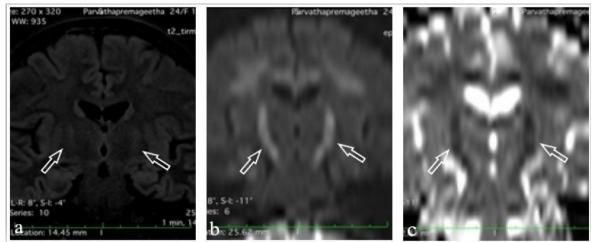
MRI coronal image of FLAIR (a), coronal reformatted images of DWI (b) and corresponding ADC mapping (c) reveals bilateral symmetrical hyperintensity with diffusion restriction (open arrows) in corticospinal tract extending from posterior limb of internal capsule, crus cerebri of midbrain and basilar part of pons.
